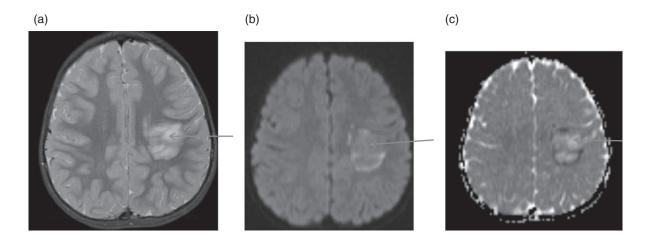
Stroke mimic/demyelination. Two-year-old female presented with acute onset of right-sided weakness. Magnetic resonance imaging (a) showed a high-signal T2 lesion in the left hemisphere not typically in vascular distribution. Diffusion-weighted imaging (b) showed a mixture of free and restricted diffusion. Apparent diffusion coefficient map (c) did not show typical restricted diffusion expected in ischaemic stroke. Follow-up imaging showed complete resolution of the lesion.
